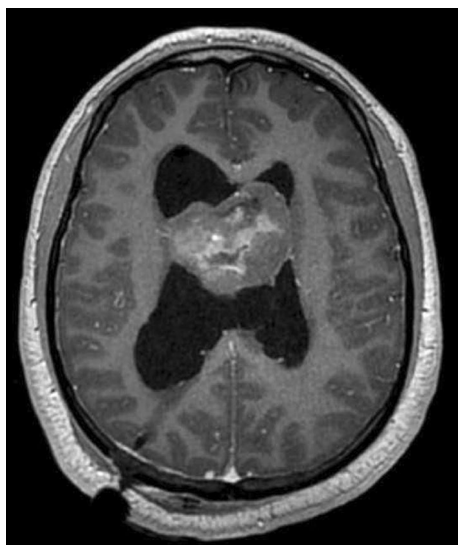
MRI axial cut for a case of neurocytoma. MRI axial cut showing central intraventricular neurocytoma with some cystic changes
